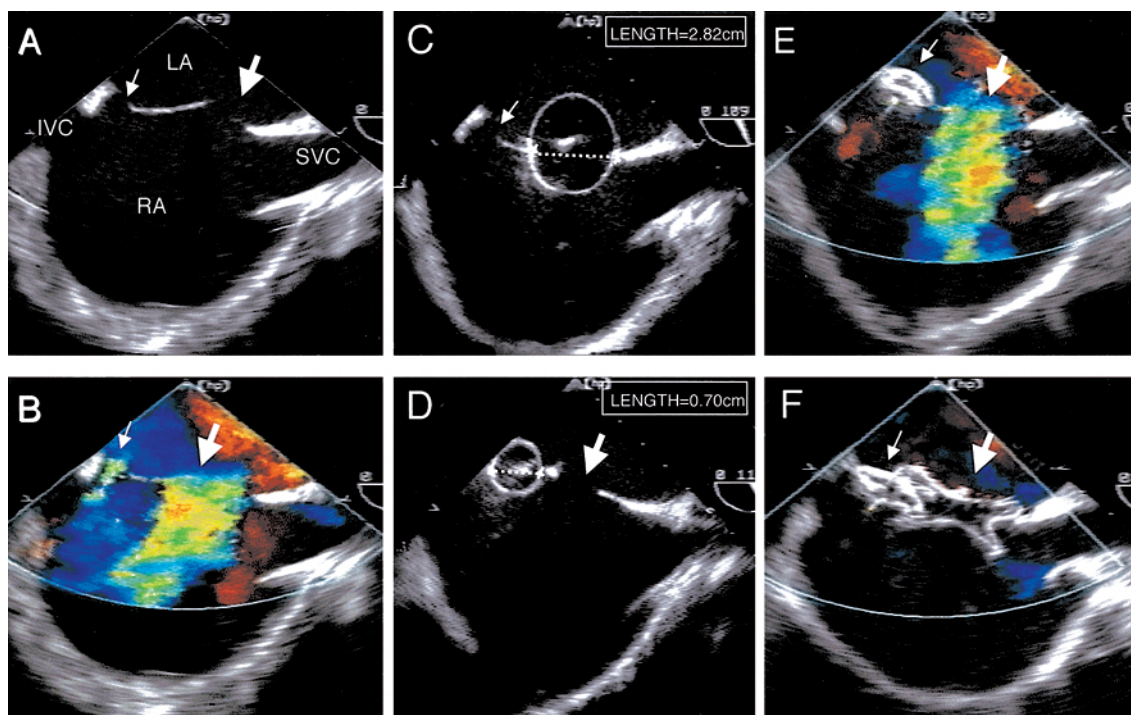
Two-dimensional transoesophageal echocardiography (TEE) imaging in the long axis (bi-caval) view (A–F). A, two-dimensional image shows a larger defect (thick arrow) and a smaller defect (thin arrow). There is enough rim between the two defects. B, colour Doppler imaging validates the existence of the two defects (thick arrow denotes the larger defect and thin arrow denotes the smaller defect). C, the stretched balloon diameter is measured for the larger defect (arrow denotes the smaller defect). D, the stretched balloon diameter is measured for the smaller defect (arrow denotes the larger defect). E, the smaller device has been deployed, but not released (small arrow), while the larger defect has not yet closed (arrow); the delivery system in the larger defect cannot be seen in this frame. F, after deployment of both devices demonstrating overlapping of both devices. Colour flow Doppler interrogation demonstrated no residual shunting. IVC = inferior vena cava; LA = left atrium; RA = right atrium; SVC = superior vena cava.
